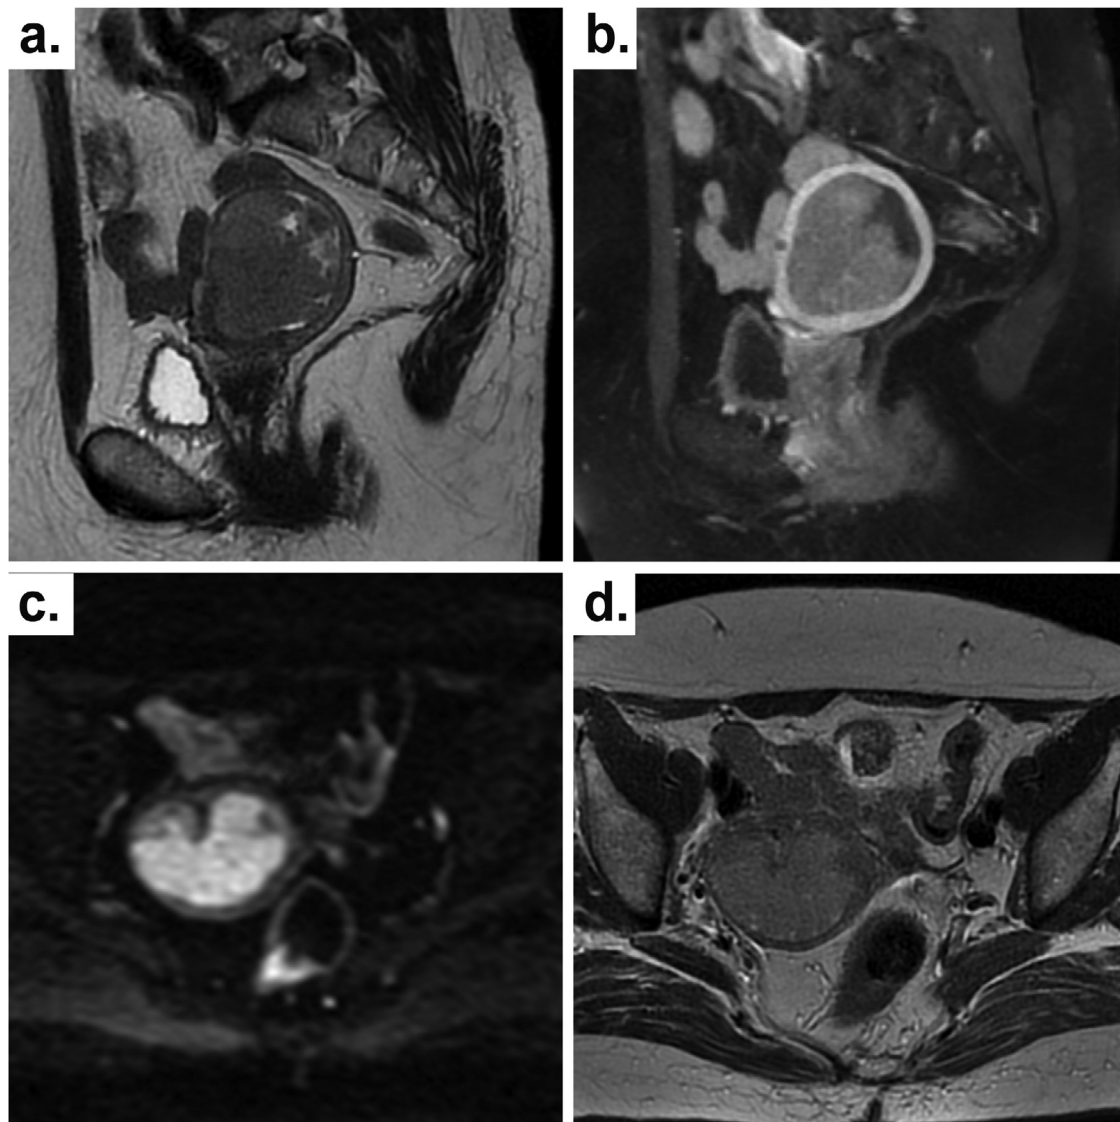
Pelvic and lower abdominal magnetic resonance imaging (MRI) examination in (A) sagittal T2 weighted image (T2WI) view and (B) sagittal T1-weighted fat-suppressed (T1FS) + contrast show the intrauterine cavity's solid and irregular mass without myometrial invasion. There were no signs of serosal invasion or cervical stromal invasion. (C) Axial diffusion-weighted imaging (DWI) on $b=1000\text{m/s}$ and (D) axial T2WI show intrauterine cavity solid mass with high diffusion restriction confined to the uterine cavity. There were no signs of lymph node enlargement in the pelvic region.
